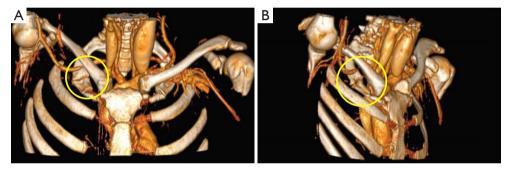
Computed tomography chest scan 3D reconstruction showing the features of a dysmorphic first rib with subclavian vein stenosis. (A) Sagittal view; (B) frontal view.
